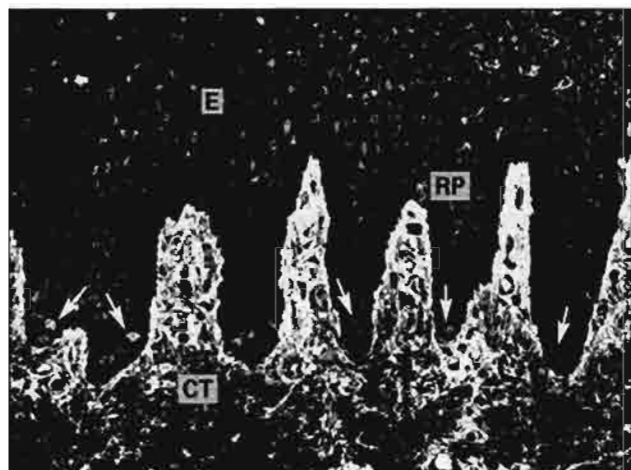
Location of Merkel cells (arrows) in the base of the epithelial rete pegs (RP) of the palate. (E) Epithelium; (CT) connective tissue. (Original magnification $\times 200$.)
